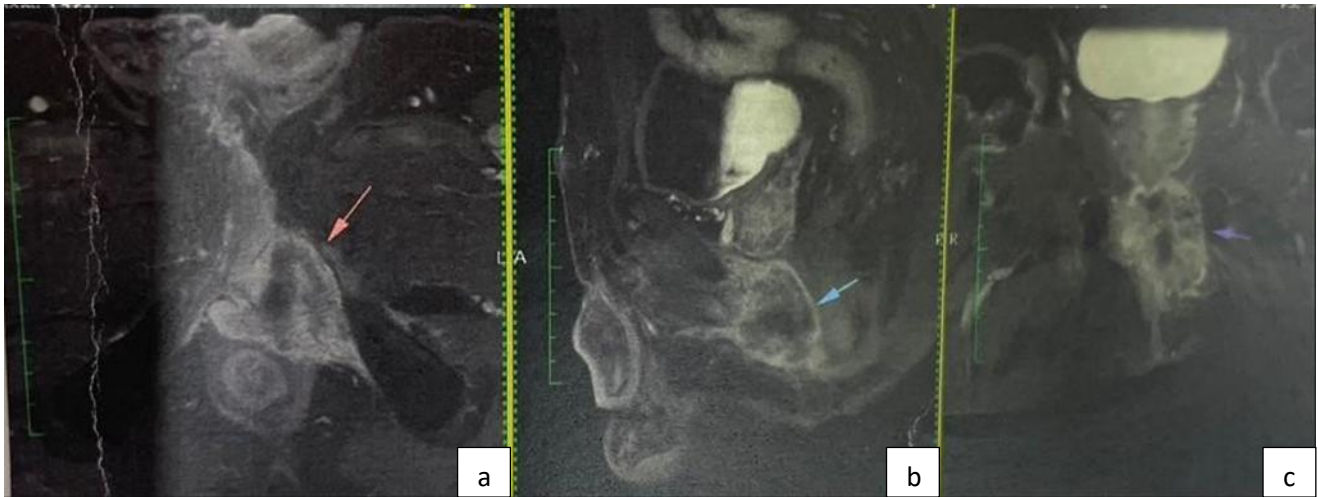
(a-c): MRI of Pelvis and Perineum showing no residual or recurrent tumour
